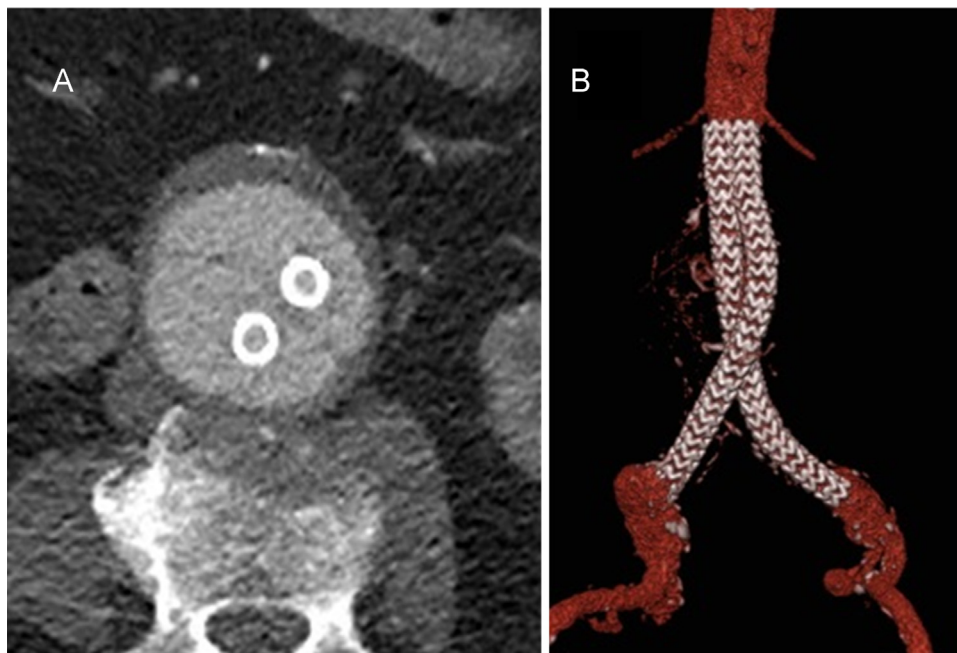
(A) Axial computed tomography (CT) showing classic “yin-yang” appearance of the stents within the endobags. (b) Volume rendered CT showing characteristic crossing stents within the aneurysm.
